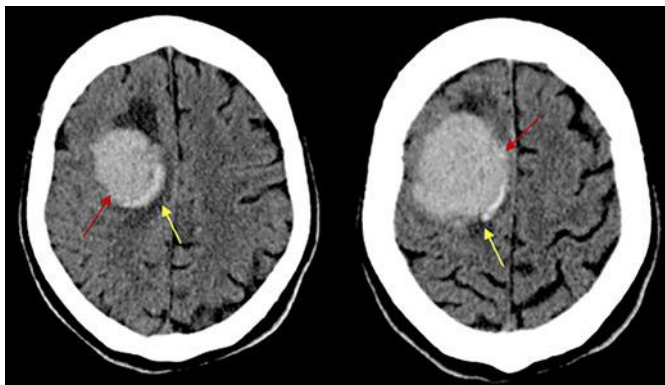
CT scan of the brain demonstrating an intraparenchymal hemorrhage area (red arrow) in the right frontal lobe. There is a surrounding edema (yellow arrow) associated with the lesion.
